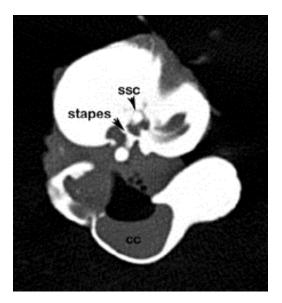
2D CT scan of melon head ear at the level of the lateral semi-circular canal (ssc). The stapes is also visible in this cross-section. The arrow is pointing to the "footplate" which is in contact with the membrane of the oval window. CT Imaging Report
